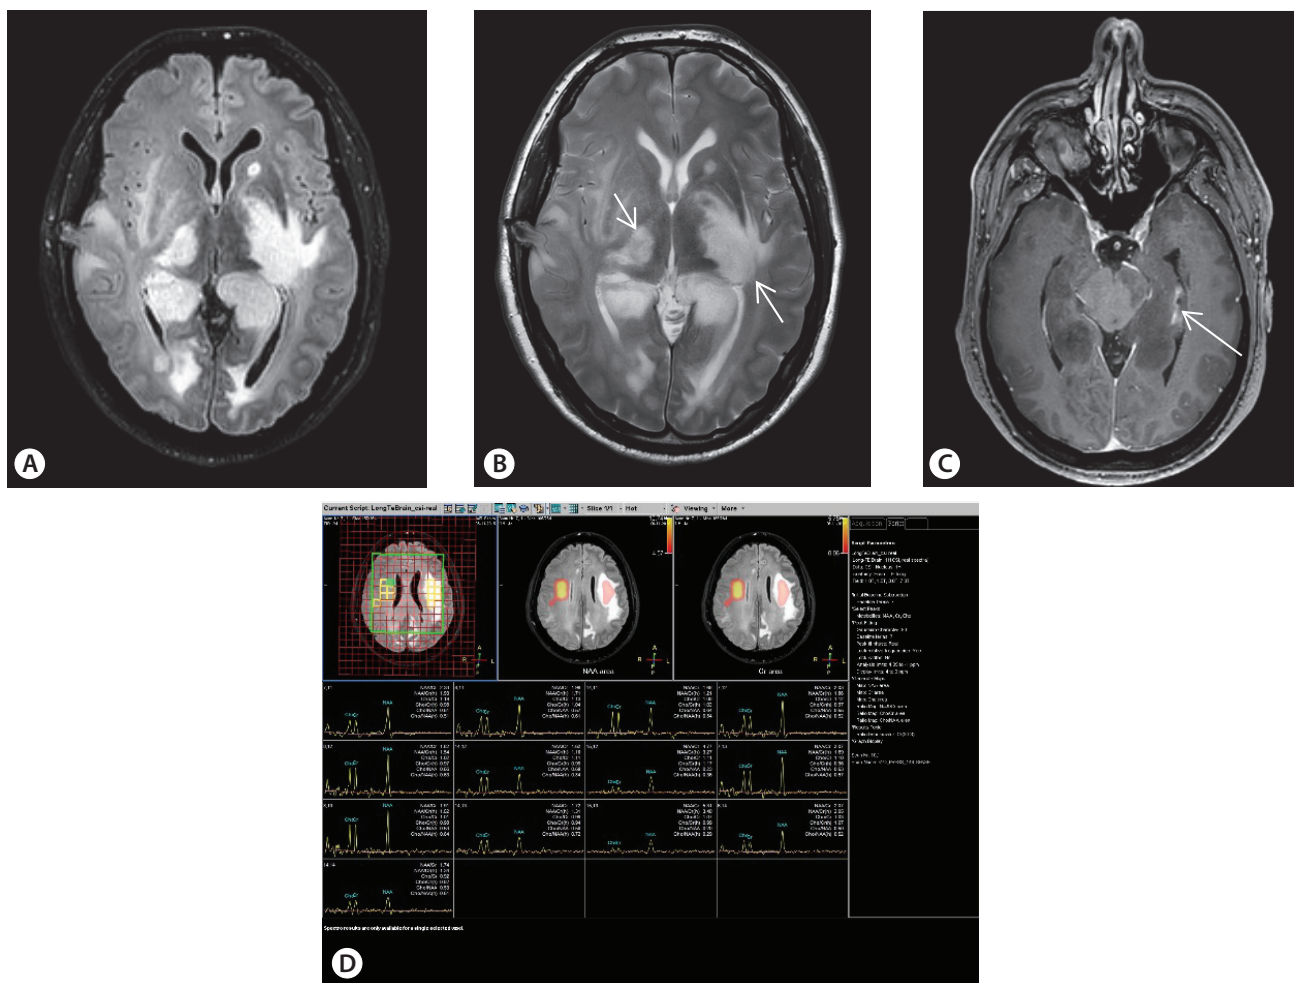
FLAIR (A), T2 (B), T1 with contrast media (C), and MRS (D) showed a diffuse, infiltrating process with FLAIR/T2-hyperintense signal, involving the posterior corpus callosum, the thalami and the parahippocampus bilaterally and extending in the temporal white matter and caudally in the mesencephalon (short arrows). MRS showed decreased NAA with minimal increase of Choline. Follow up MRI (C) showed a new nodular contrast enhancement in the occipital horn of the lateral ventricle left (long arrow).
